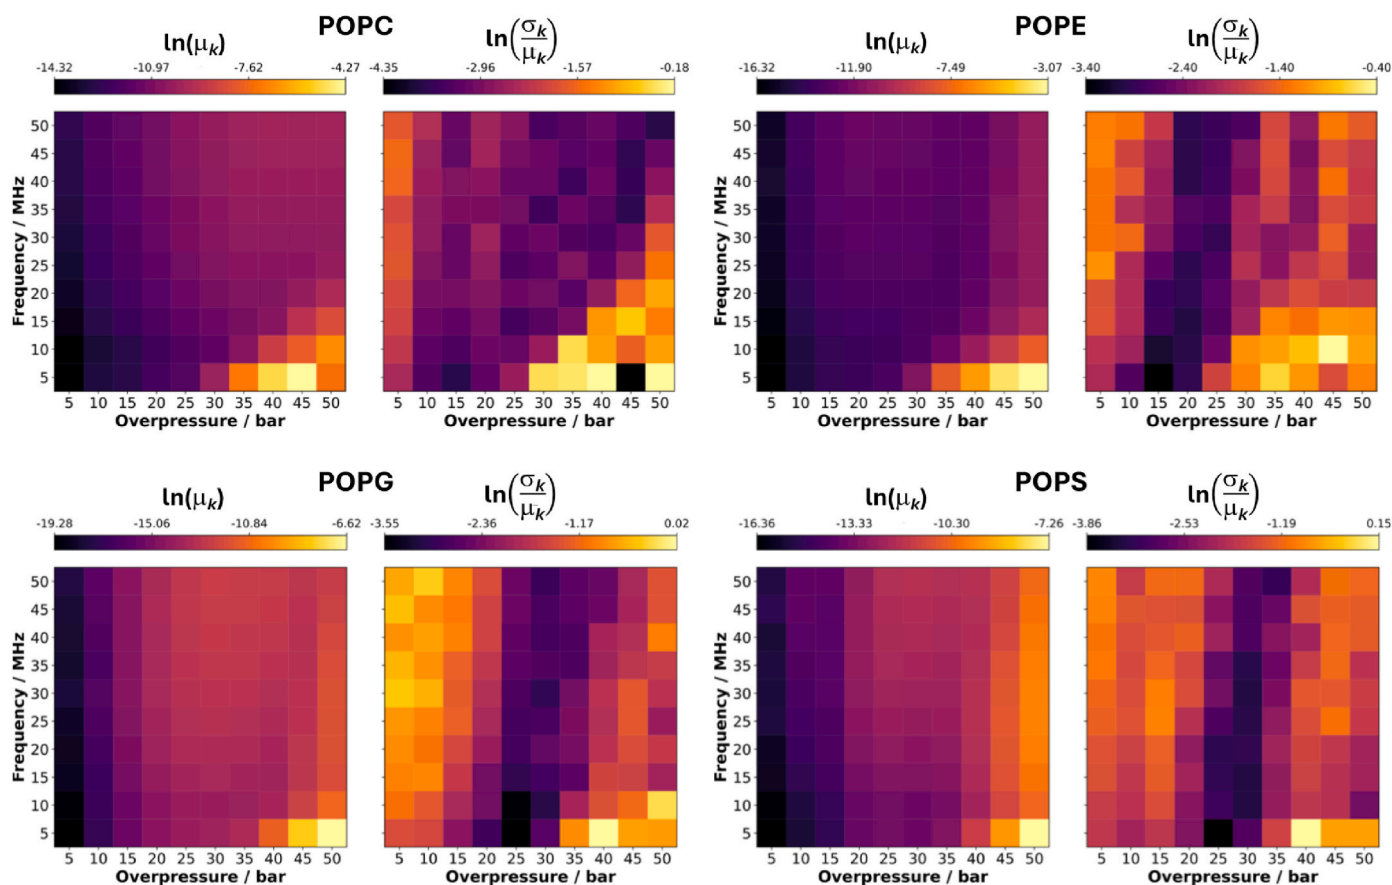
Curvature (k) response for the studied systems under varying ultrasound conditions. Two heatmaps are plotted for each lipid bilayer: Logarithm of mean curvature, $\ln(\mu_k)$, showing average membrane expansion or compression (left); and Logarithm of relative k fluctuations, $\ln(\sigma_k/\mu_k)$, indicating the magnitude of k variations relative to its average value (right). Color scale: Blue indicates lower values, red higher values. This logarithmic representation enhances visibility of subtle variations across different ultrasound parameter regimes. (For interpretation of the references to colour in this figure legend, the reader is referred to the Web version of this article.)
